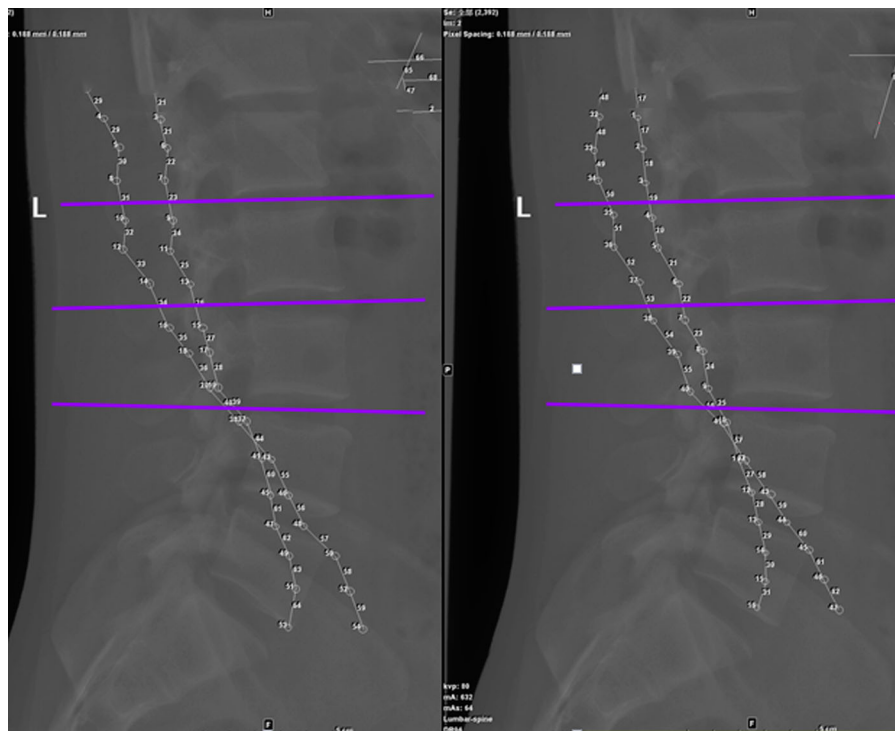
Continuous graph of the puncture point and the lowest point of the posterior renal fascia on the lateral lumbar X-ray. (A) continuous graph of the right side of the puncture point and the lowest point of the posterior renal fascia; (B) continuous graph of the left side of the puncture point and the lowest point of the posterior renal fascia; Line 1: refers to the puncture point of the line that is the safety line; Line 2: refers to the final point of the renal fascia connection.
